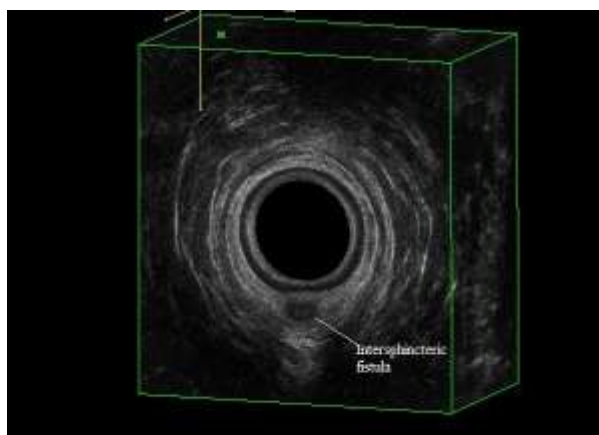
Unenhanced 3D Endoanal ultrasound scan image of posterior intersphincteric fistula.
